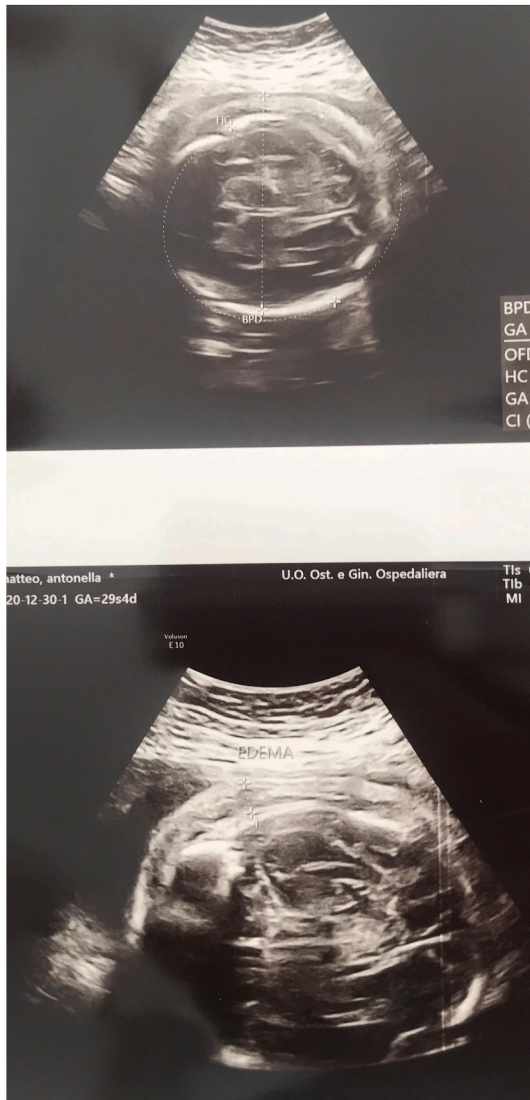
Prenatal ultrasound at 29 th week of gestational age showing abdominal fluid collection and hydrops.
